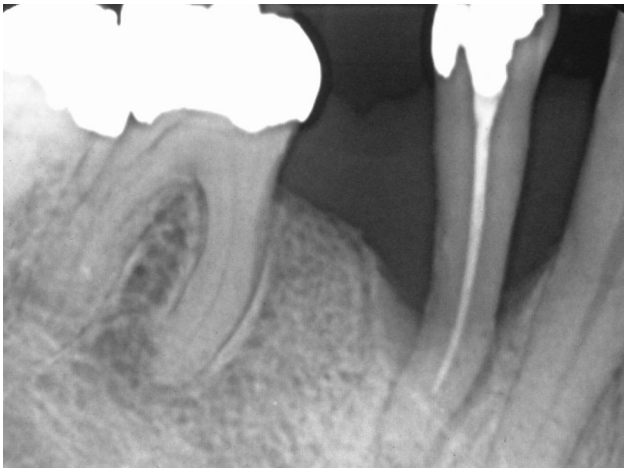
Periapical radiograph showed bone loss on tooth 44
